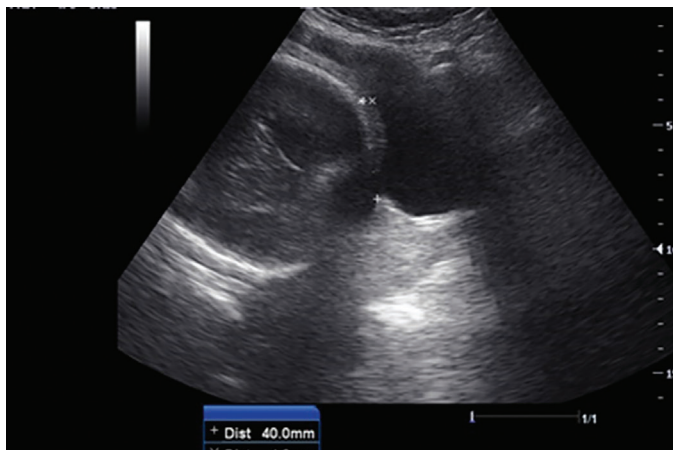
Transabdominal ultrasound image of the measurement of preoperative anterior wall myometrial thickness
